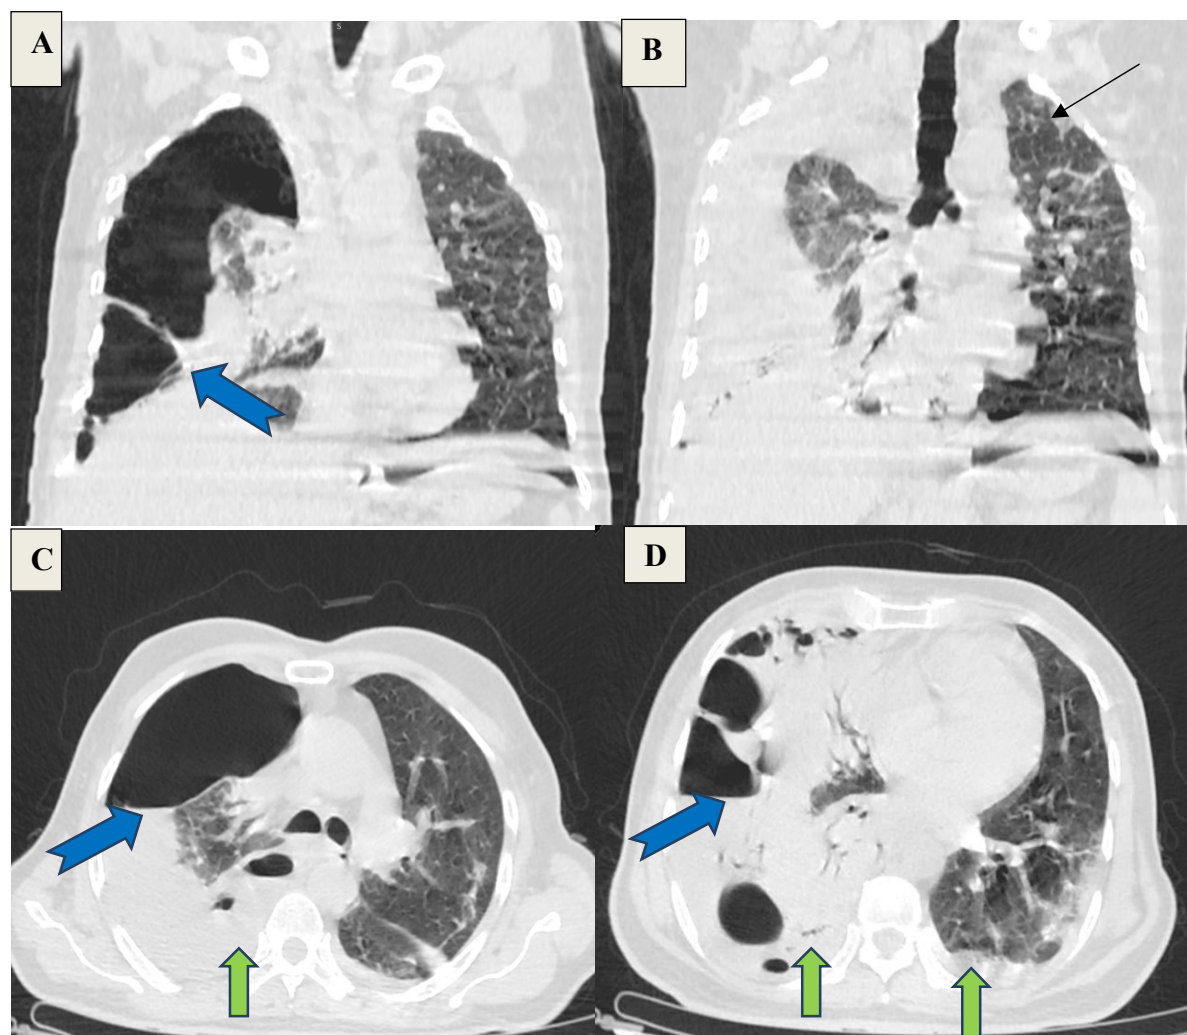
A,B,C&D) a 60 year old male with chronic history of smoking, coronal and axial sections of CT Chest shows hydropneumothorax(blue notched arrow) with complete collapse of right lower lobe and partial collapse of right upper lobe and consolidation changes(green arrow) in bilateral lung fields. And few patchy ground glass opacities(black arrow) in left lung. RTPCR positive - CORADS-6 Category.
